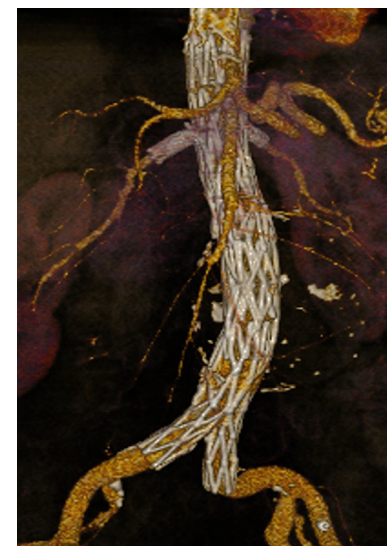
Computed tomography angiography with three-dimensional volume rendering technique demonstrating a fenestrated cuff with two small fenestrations (renal arteries) and a scallop (superior mesenteric artery) deployed within the pre-existing Powerlink stent-graft (Endologix, Irvine, CA, USA).
